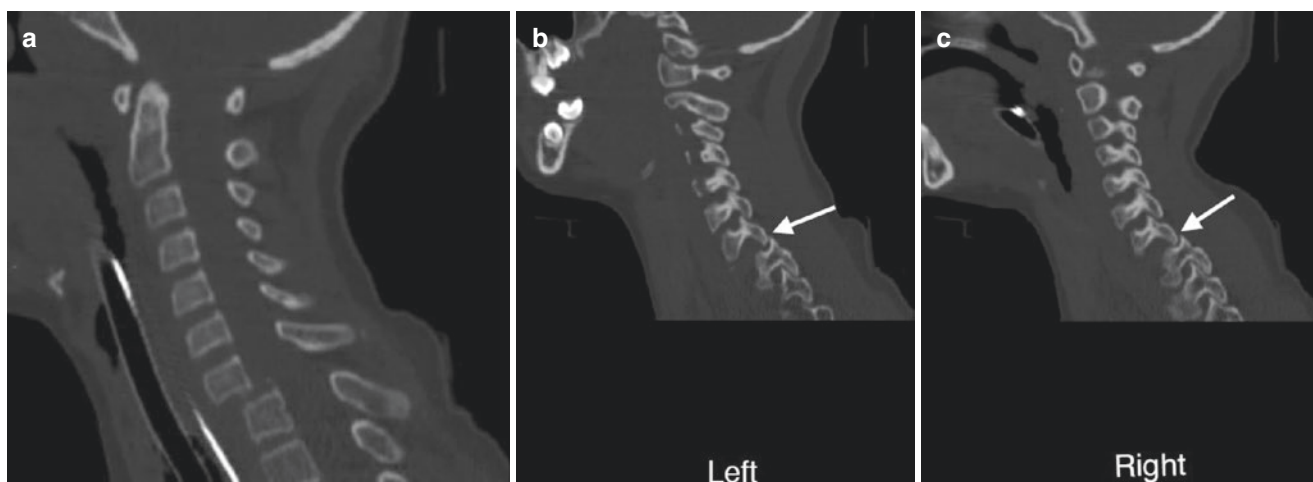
Fracture dislocation at C7/T1. (a) Midline sagittal reformatted CT image of the cervical spine demonstrates a horizontal fracture through the inferior aspect of the C7 vertebral body and a further fracture
